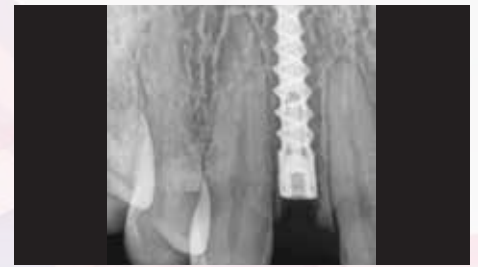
Postoperative radiograph verified that the implant was fully seated and didn't impinge upon the periodontal ligament spaces of the adjacent teeth.
